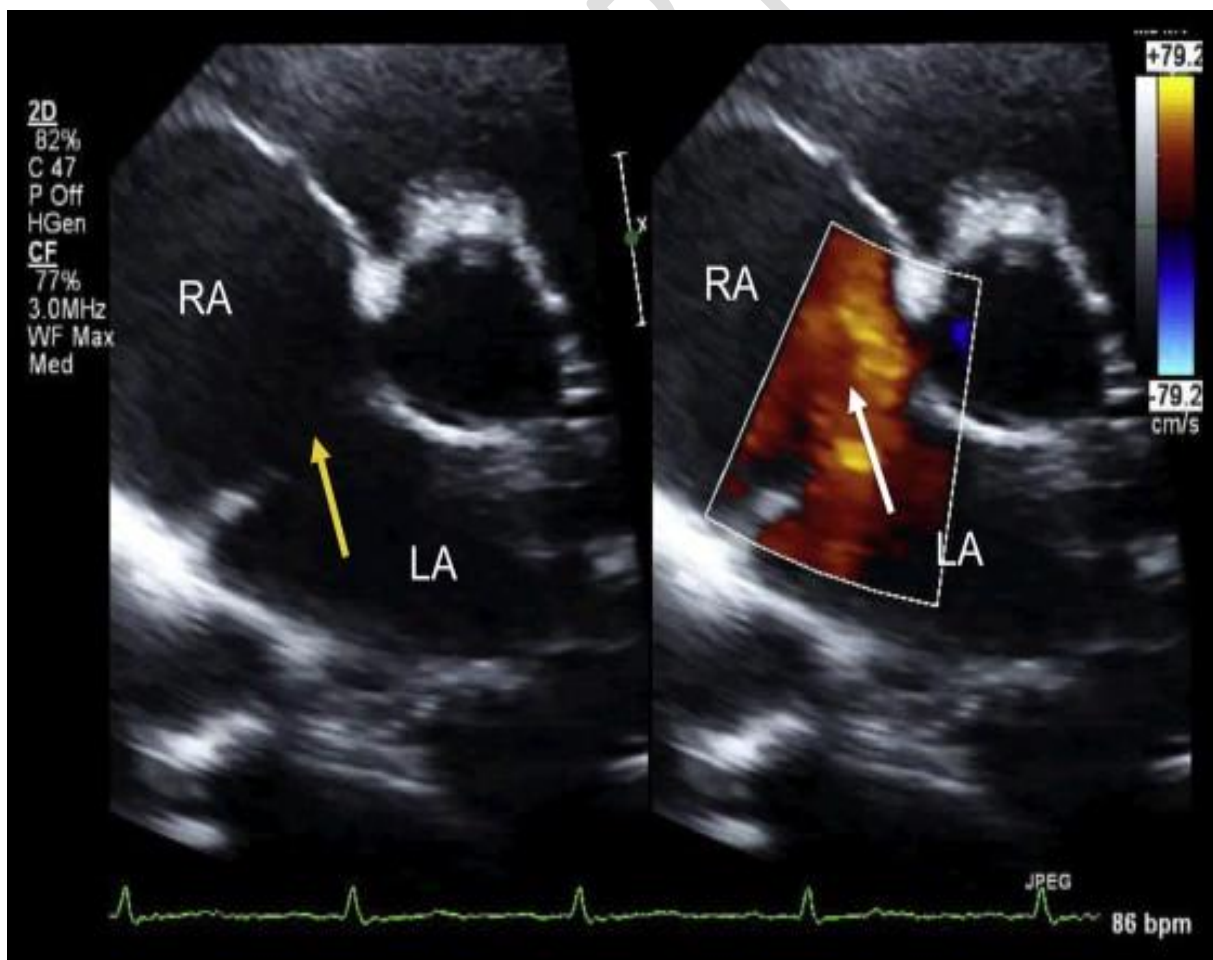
echocardiography shows Atrial Septal Defect (14)
